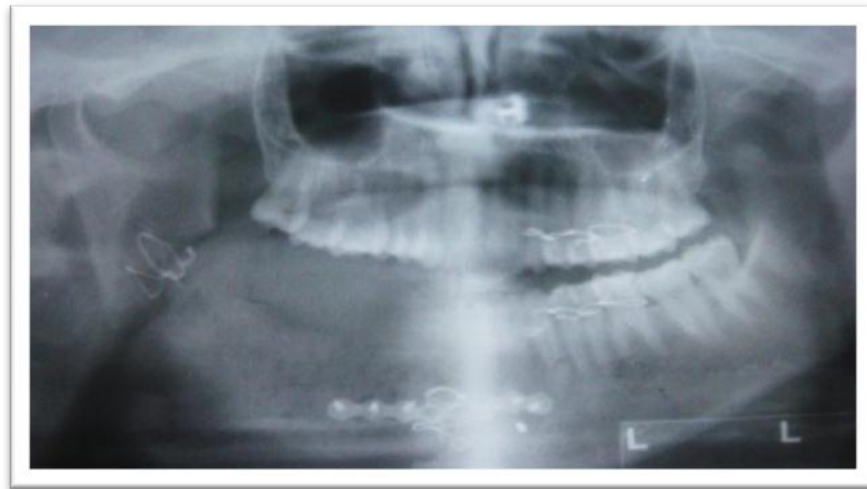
Post-surgical intraoral, extra oral and radiographic picture of the patient
